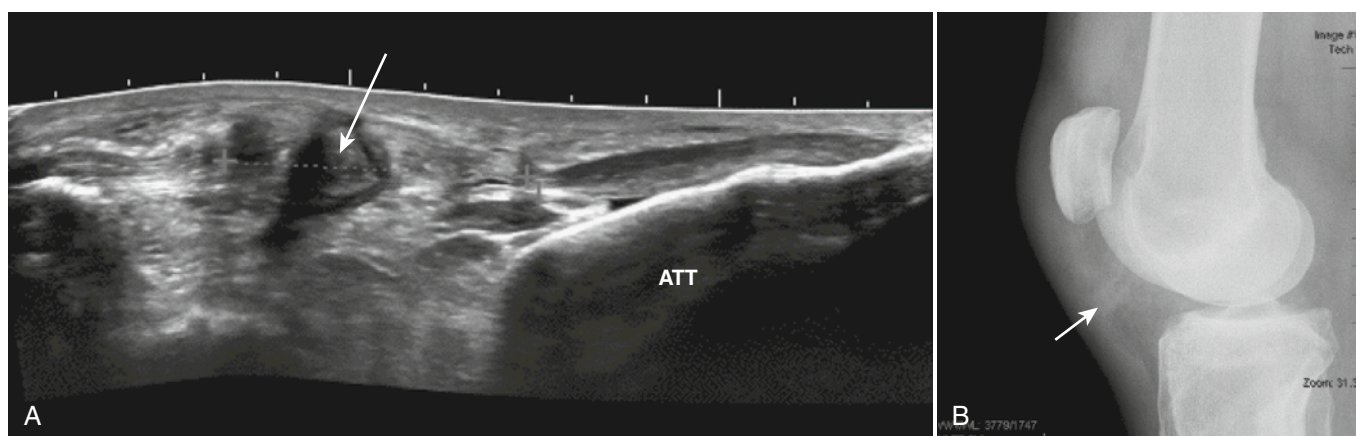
A, Patellar tendon tear seen as a distorted fibrillar pattern (arrow) with a hypoechoic hematoma. B, Indistinct silhouette of the patellar tendon on a radiograph. ATT, anterior tibial tuberosity.
